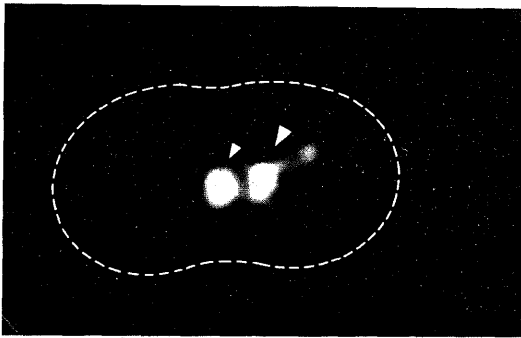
$^{18}\text{F}$ FDG による肺癌のポジトロン CT 像。主病巣 (大矢印) および縦隔リンパ節 (小矢印) に高度の集積がある。このため、胸郭の輪郭はほとんど見えない (破線で示してある)。
